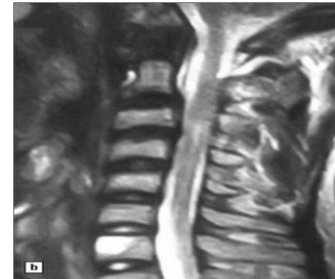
MRI revealed a moderate left posterolateral disc herniation at C3–C4 with mild compression of the spinal cord.
